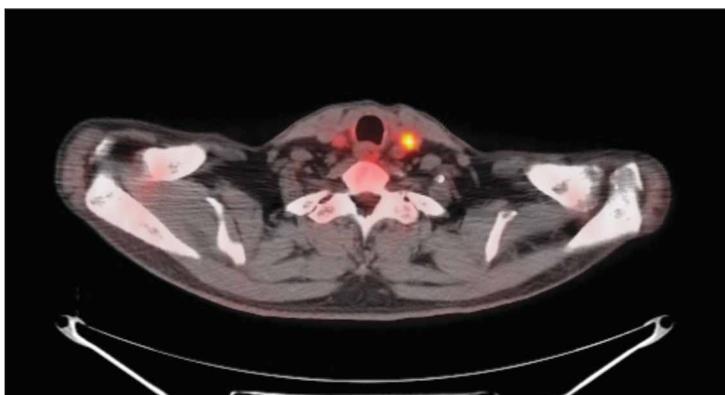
Outside axial [^{18}F]FDG-PET/CT shows no hypermetabolic lesion in the left carotid space.
